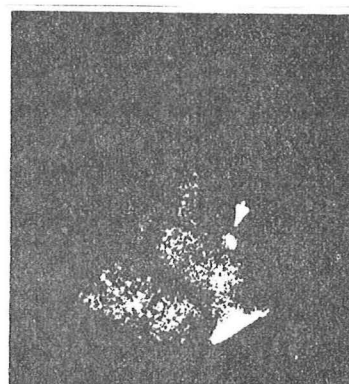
Filling defects seen at both end-diastole and end-systole in the anterior and left anterior oblique (LAO) views of a radionuclide MUGA scintigram of a patient with left ventricular mural thrombus.
